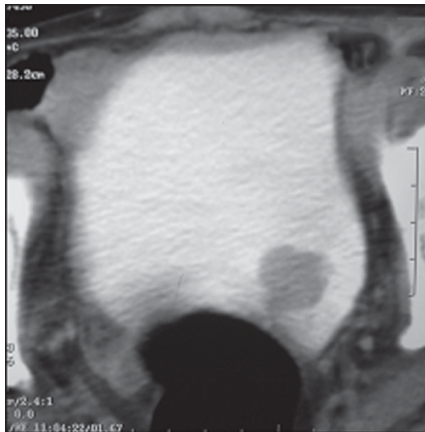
Contrast-enhanced computed tomography: Moderately enhancing lesion in the left postero-inferior wall of the bladder
